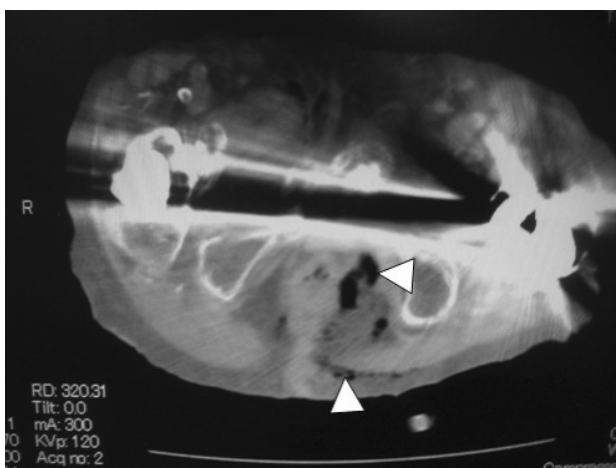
Computed tomography. Arrow head : air density in the subcutaneous tissue
